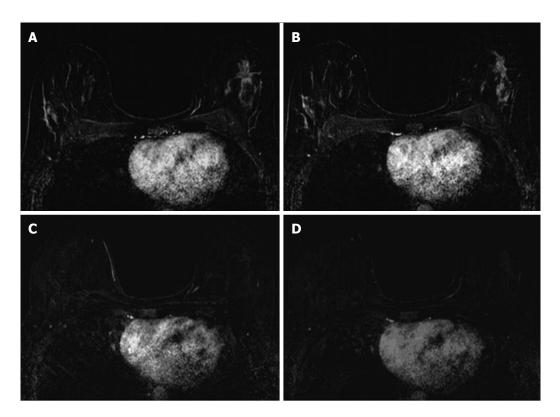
Thirty-seven years old woman with HR+ left breast cancer. A and B: Baseline axial T1-weighted post-gadolinium fat-saturated magnetic resonance image demonstrates a speculated mass and contiguous non-mass enhancement extending posteriorly for a total of 7 cm of disease in the upper outer breast; C and D: Post-neoadjuvant chemotherapy magnetic resonance imaging demonstrates decrease in size and degree of enhancement of prior findings. Surgical pathology demonstrates 6.9 cm of invasive ductal carcinoma.
